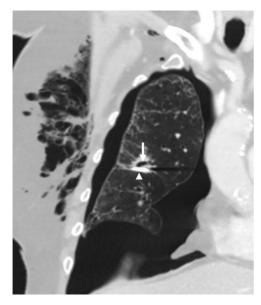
Preprocedural coronal computed tomography (CT) thorax showing a pneumothorax, the bronchopleural fistula (*arrow*), and the retained needle ablation tip adjacent to the fistula (*arrowhead*).
